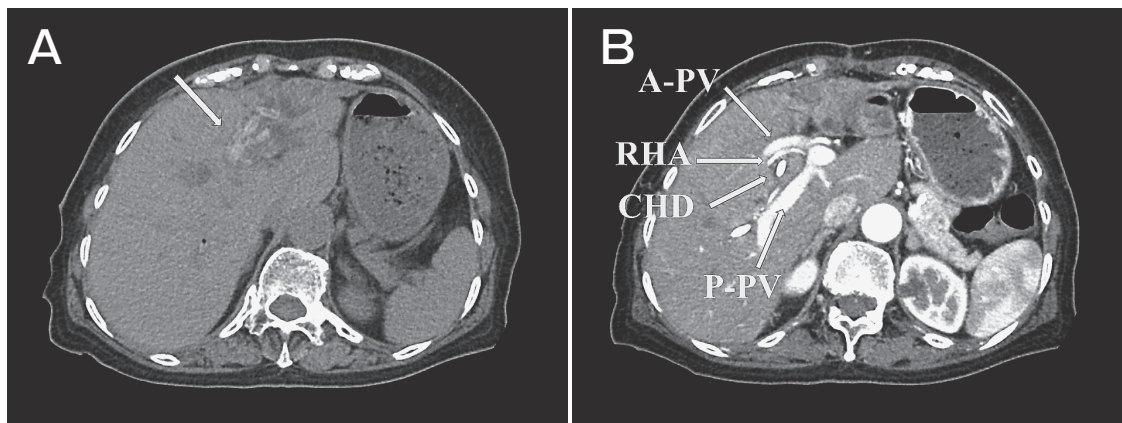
Preoperative computed tomography images. A, The left lobe of the liver is atrophied, and the left intrahepatic duct is completely occluded by diffuse intrahepatic stones (arrow). There is bilateral dilatation in the intrahepatic bile ducts; B, The right hepatic artery and anterior branch of the portal vein pass in front of the common hepatic duct. The left branch of the portal vein is not enhanced due to the obstruction.
